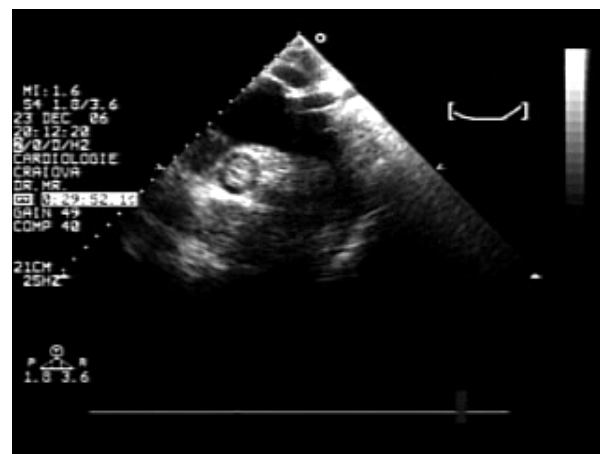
Transthoracic echocardiography, suprasternal incidence showing dilated aortic crosa, without dissection, and a hypoechoic thrombus in the pulmonary artery.
